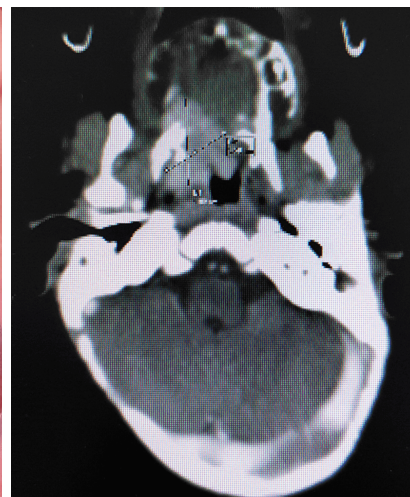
CT scan appearance of the soft palate and lateral pharynx wall tumor. CT: Computed tomography.
